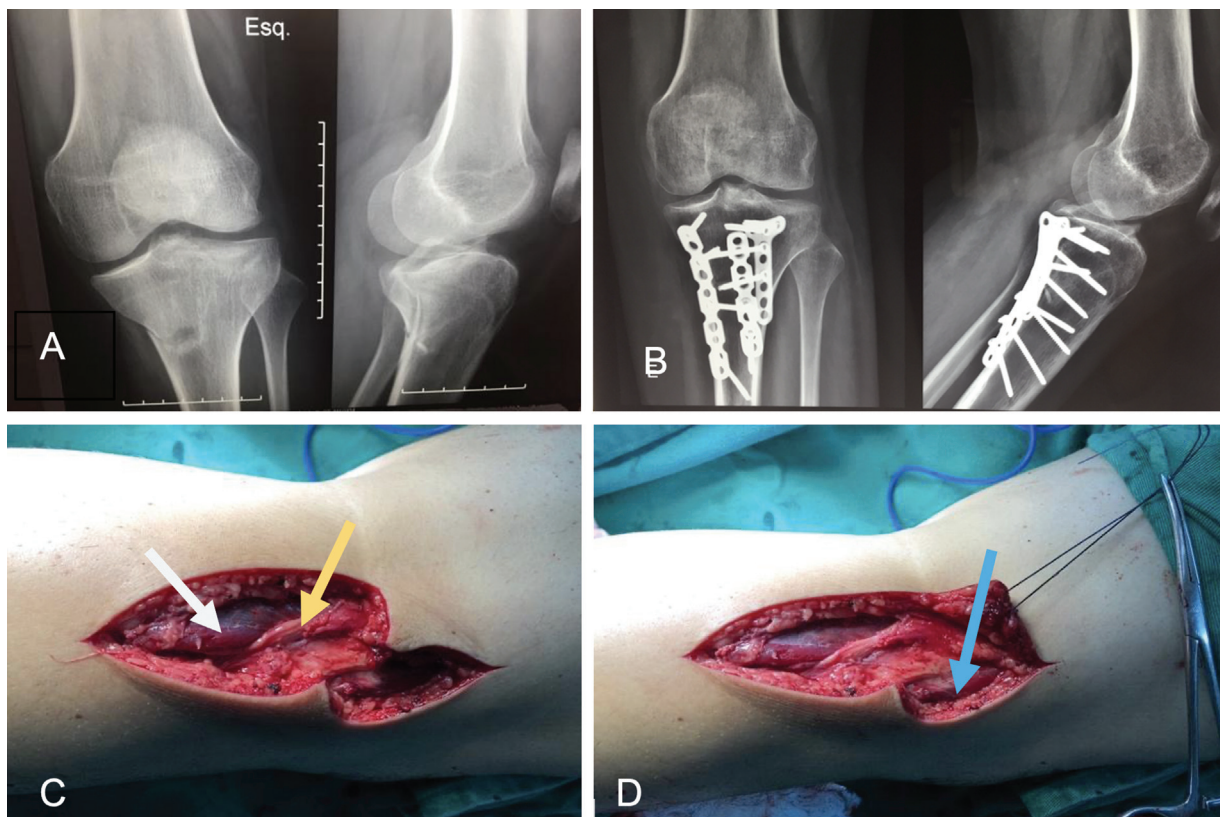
(A) Anteroposterior and lateral radiographs showing a fracture of the posterior column of the left tibial plateau. (B) Postoperative images of anteroposterior and lateral radiographs of the left knee evidencing fracture reduction and internal fixation with a 3.5-mm T plate (Lateral) + 3.5 reconstruction plate (medial) + 3.5 reconstruction plate (central). (C and D) Intraoperative images showing a lateral Carlson incision in a posterolateral curvilinear "S" shape. White arrow - Lateral head of the gastrocnemius muscle. Yellow arrow - Fibular nerve. Blue arrow - Lateral head of the biceps femoris muscle.
